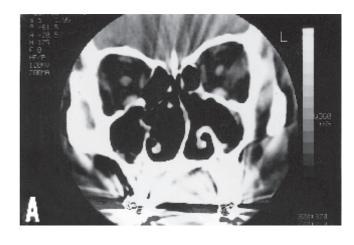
Post-operative contrast-enhanced paranasal sinus coronal (A) and axial (B) CT-scans, showing no recurrence of the pathologies after 12 months.
